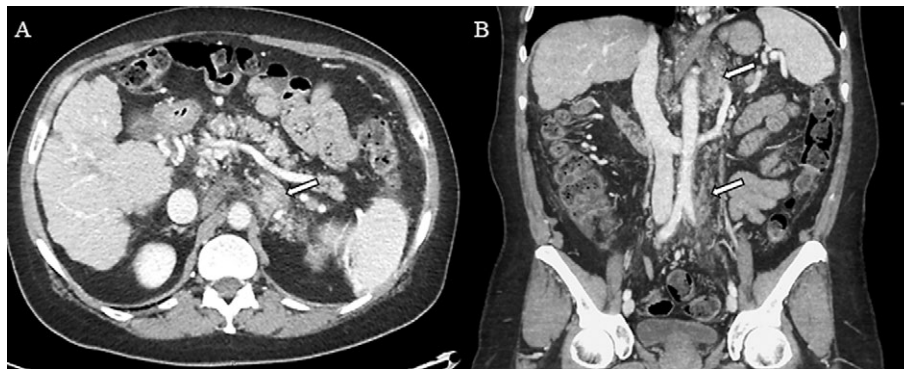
A, B) Computed tomography images demonstrated inflamed retroperitoneal tissue, especially localized in the left para-aortic space (A) and not extended below the aortic bifurcation (B).
